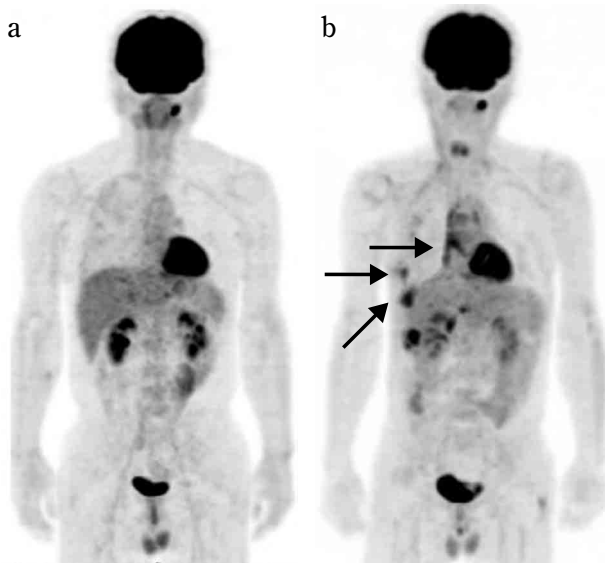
Fifty-one year-old male. a) PET image at initial diagnosis. FDG-PET/CT demonstrated a slight diffuse uptake along the pleura. There was no evidence of lymph node metastasis or distant metastasis. His disease progressed very rapidly and extrapleural pneumonectomy one month after PET/CT examination confirmed pT3N2. b) PET image at follow up (10 months after 1st PET/CT). Recurrent lesions show FDG positive (arrow).
